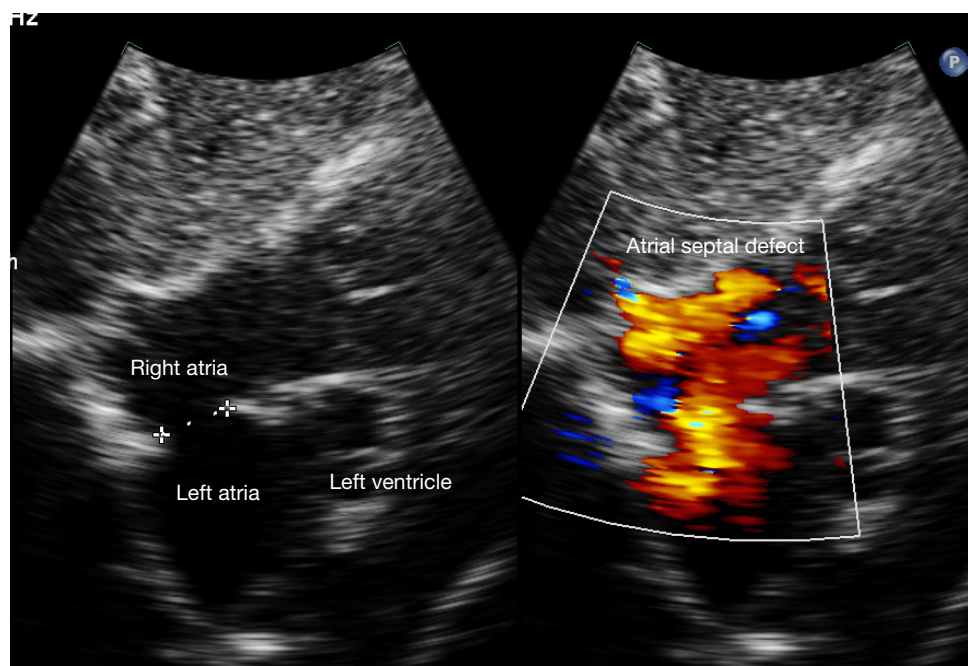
A two-dimensional transthoracic echocardiogram (subcostal four-chamber view) demonstrating a 1.67 cm secundum atrial septal defect (left) with Doppler colour flow (red), showing a left atrial to right atrial shunt (right).
